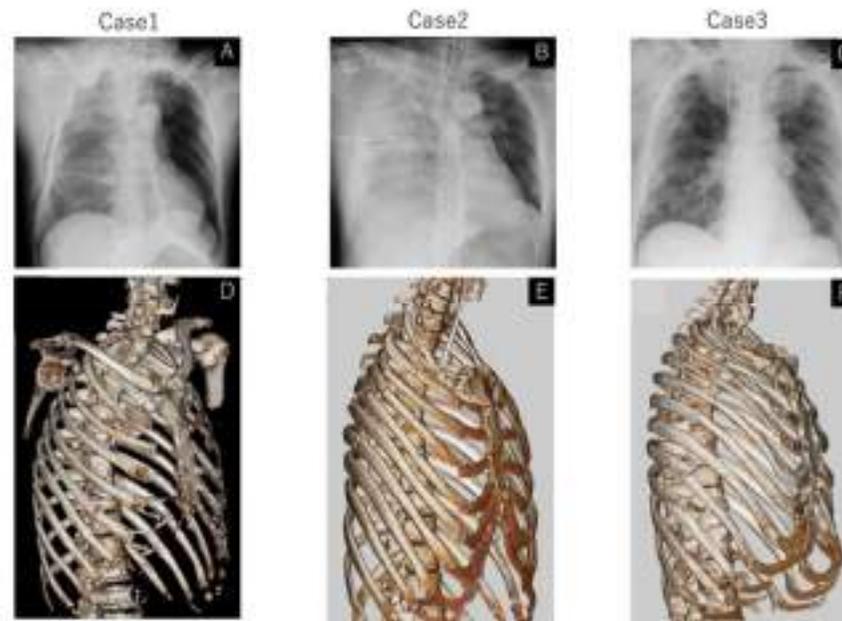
Chest radiograph and computed tomography (CT) image of the ribs. The chest radiograph shows hemothorax, and the CT image shows multiple rib fractures. Case 1 (A, D), Case 2 (B, E), Case 3 (C, F).
